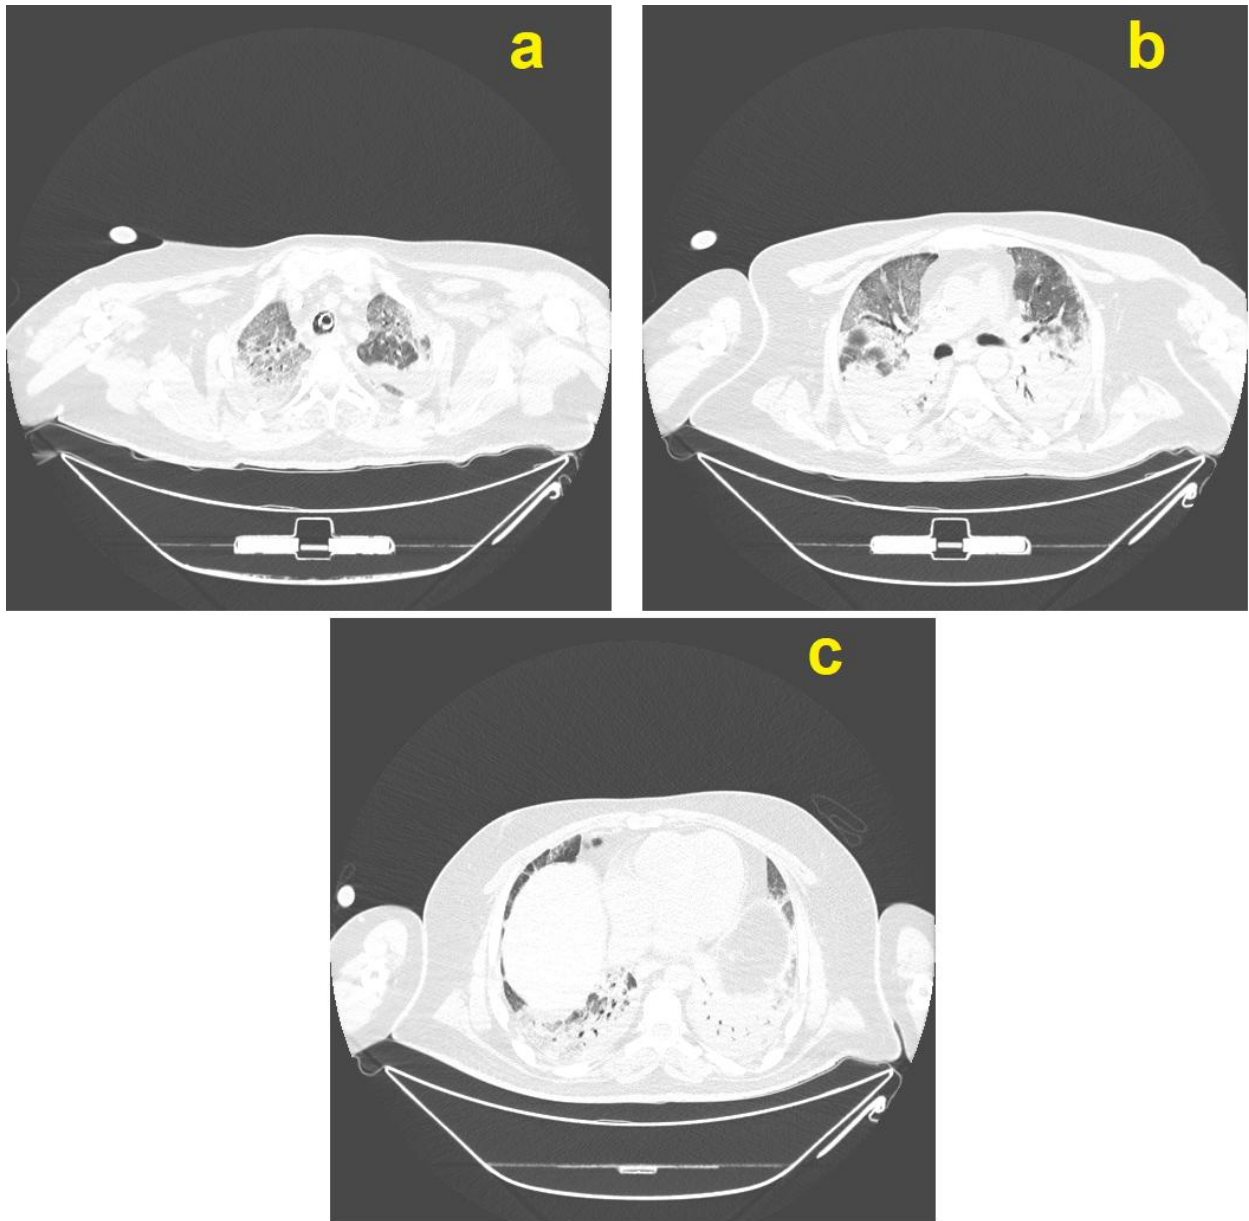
(a,b and c): HRCT-chest
